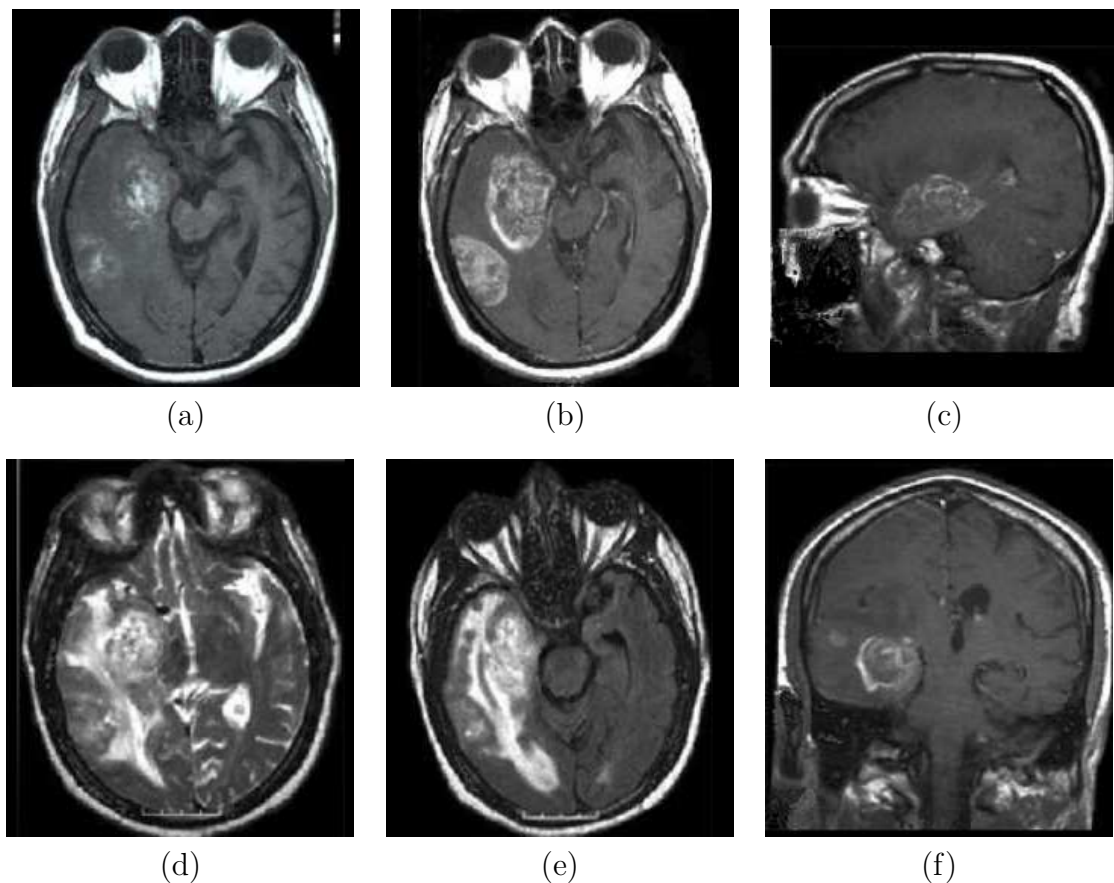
Glioblastoma multiforme. a) Axial slice of T1-weighted image without contrast enhancement. b) Same slice with contrast enhancement. c) Sagittal view of this tumor. d) T2-weighted image of the same tumor with surrounding edema. e) FLAIR image. f) Coronal slice of T1-weighted image [Emedicine, 2005].
